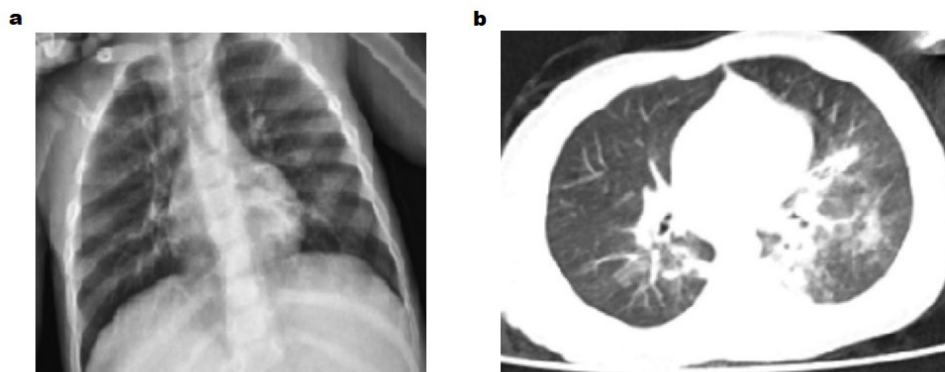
a. Pneumonic infiltration in bilateral lower zone in a posterior anterior chest X-ray, b. Consolidated area in bilateral lung parenchyma and ground-glass density image around it in thorax CT
